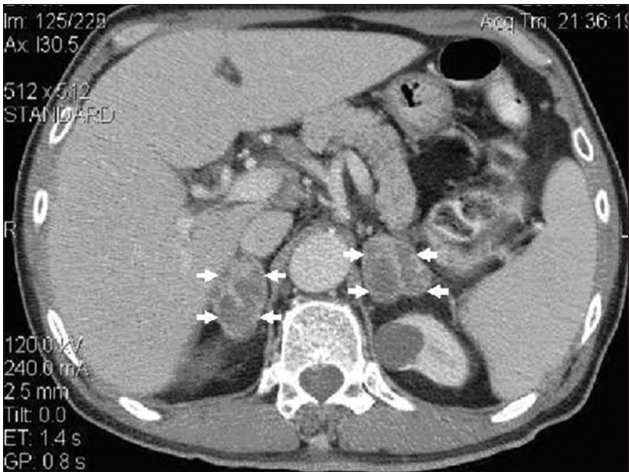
Computed tomography-scan showing bilateral enlargement of adrenal glands with central hypodense areas surrounded by a peripheral rim of enhancement
